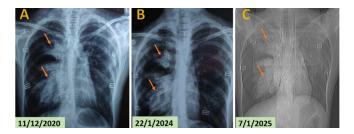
Posterior-anterior chest X-ray A) on 2020, B) on 2024, C) on 2025: Shows a lobulated outline of elongated branching opacities arising from the right hilum extending to the upper, mid, and lower zones (orange arrows).
